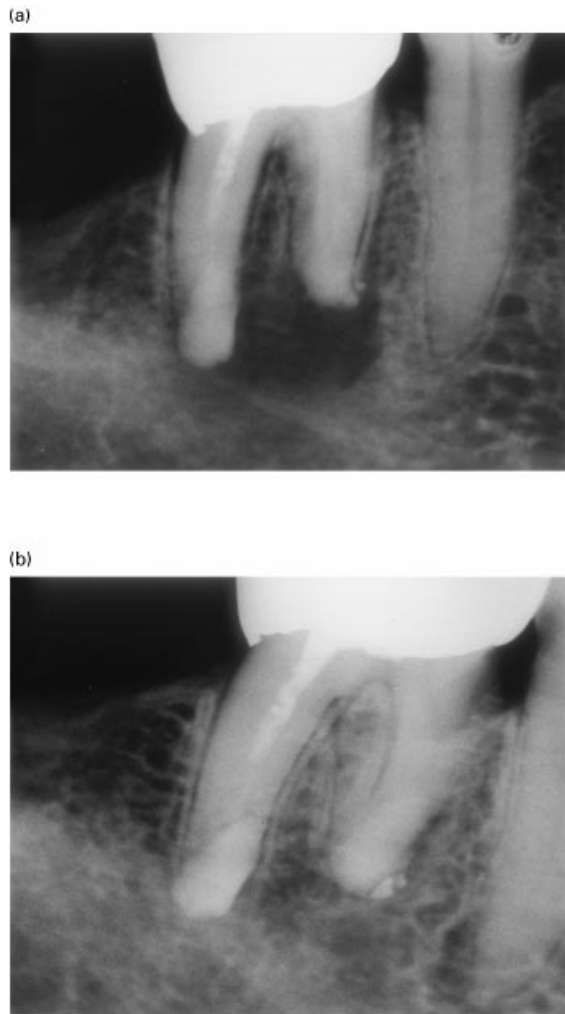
Periapical rarefaction from roots of first mandibular molar. Abscess. Eighty-nine-year-old female. a) Postoperatively. Retroplast on both root-ends; b) Six years later. Complete healing of root-ends.
